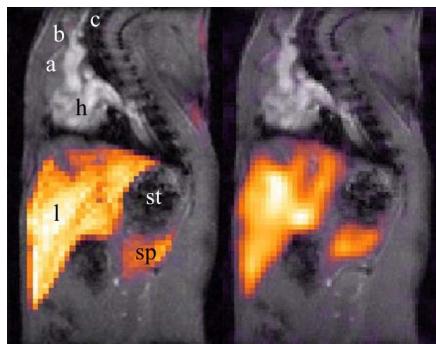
In vivo ^{19}F MCSS-RARE (left) and FuTSI (right) overlaid on ^1H MRI. a) aorta, b) brachiocephalic artery, c) right carotid, h) heart, l) liver, sp) spleen, st) stomach.
